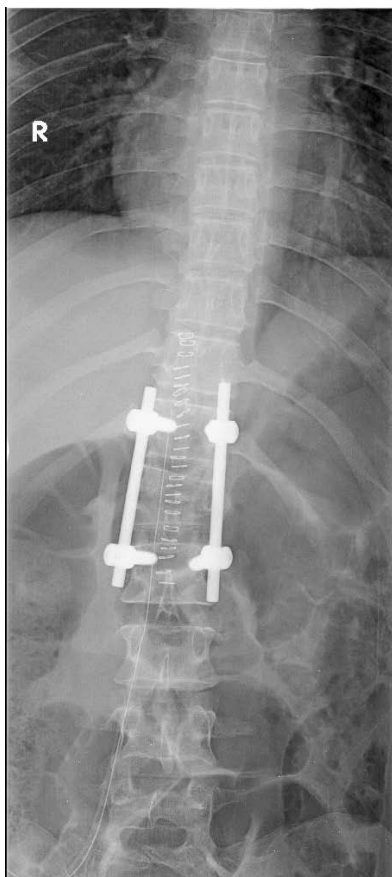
post operative radiographs
